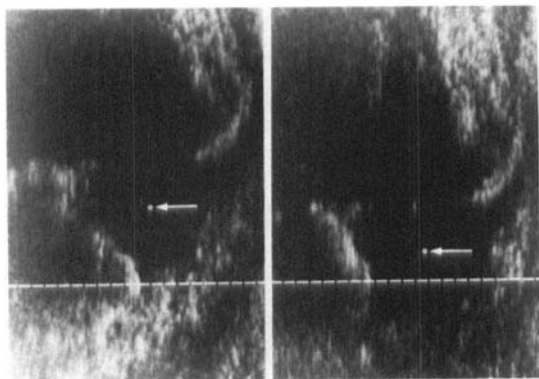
Ultrasonogram of the dislocated femoral head with the hip flexed. A dotted line is drawn between posterior edges of the acetabulum. Arrow indicates the center of the femoral head. The left picture was obtained when the knee was flexed and the right one when the knee was extended. When the knee is extended, the dislocated femoral head displaces more posteriorly to the acetabulum.
